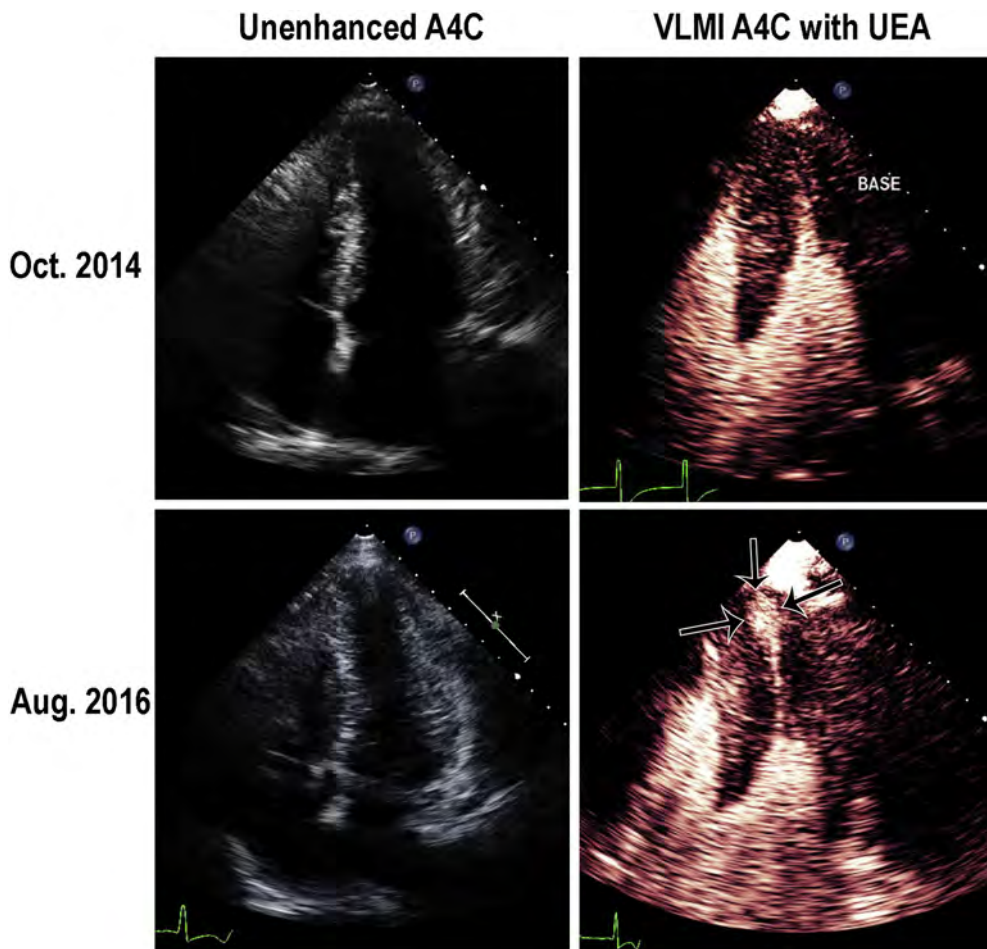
Apical four-chamber end-systolic images of a patient with apical hypertrophic cardiomyopathy. Unenhanced images (*left*) fail to delineate endocardial border, but VLMI images during a continuous infusion of a UEA (*right*) demonstrated apical hypertrophy in October 2014. Over approximately 2 years, VLMI imaging detected the interval development of an apical aneurysm. The patient subsequently had an implantable defibrillator placed.
